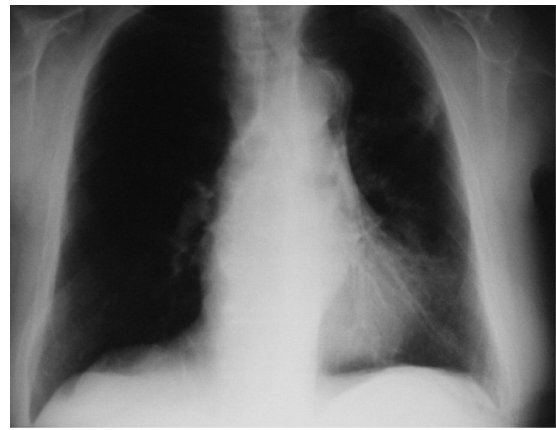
Chest X-ray on dismissal.
